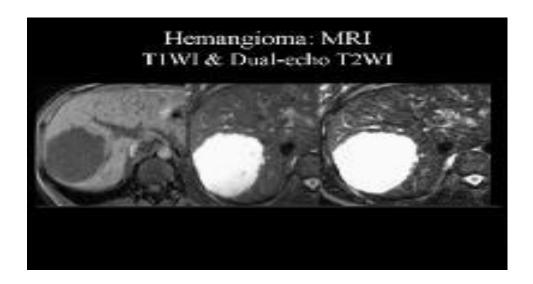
Magnetic resonance image (MRI) of a hemangioma. The lesion appears as a hypointense mass on T1-weighted MRIs (T1WI) and as a hyperintense mass on dual-echo T2-weighted MRIs (T2WI). Note that the signal intensity of the lesion is similar to that of the adjacent cerebrospinal fluid.
